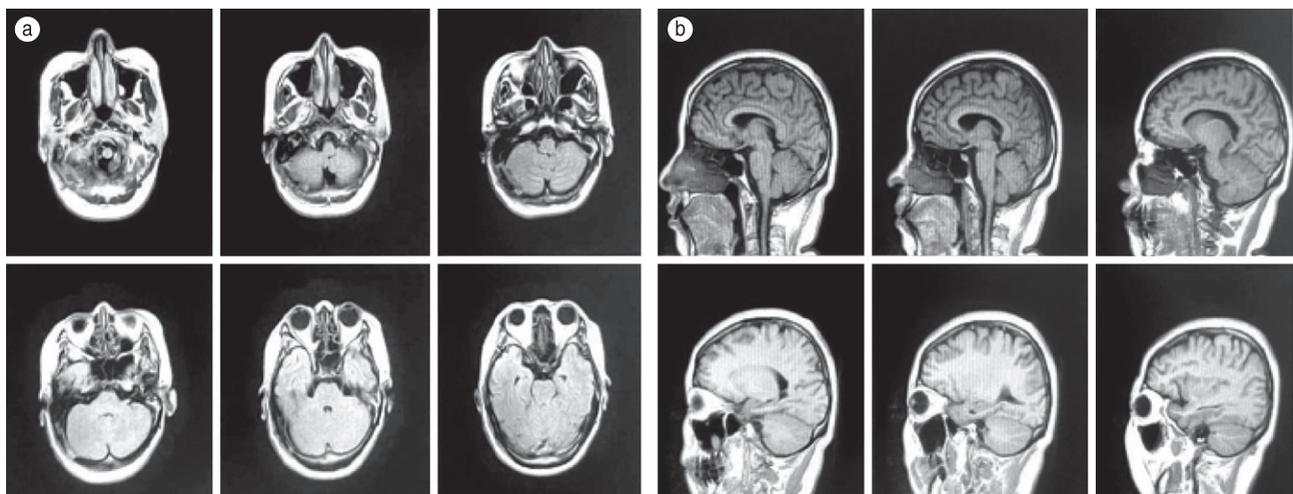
Imaging results of 2 years after operation (a and b). There is no recurrence of the tumor on magnetic resonance imaging
